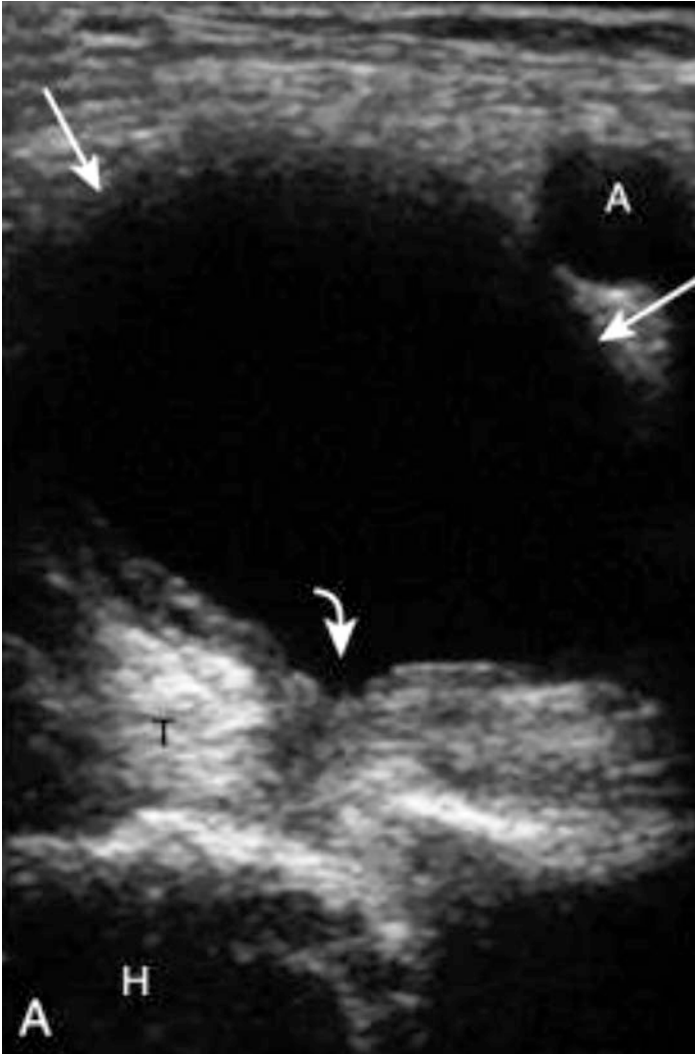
Ultrasound image shows anechoic distention of the iliopsoas bursa as shown by the arrows. H = transverse of femoral head, T = psoas major tendon, A = femoral artery. (Adapted from Jacobson, J 2018 [9])
